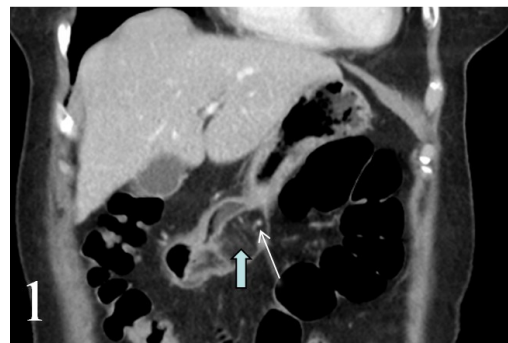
Computed tomography enhanced coronal reorganization image, visible fiber interval (short thick arrow), and enhanced vascular shadow (long arrow) in a female aged 67 years and with large curved gastric lipoma.
